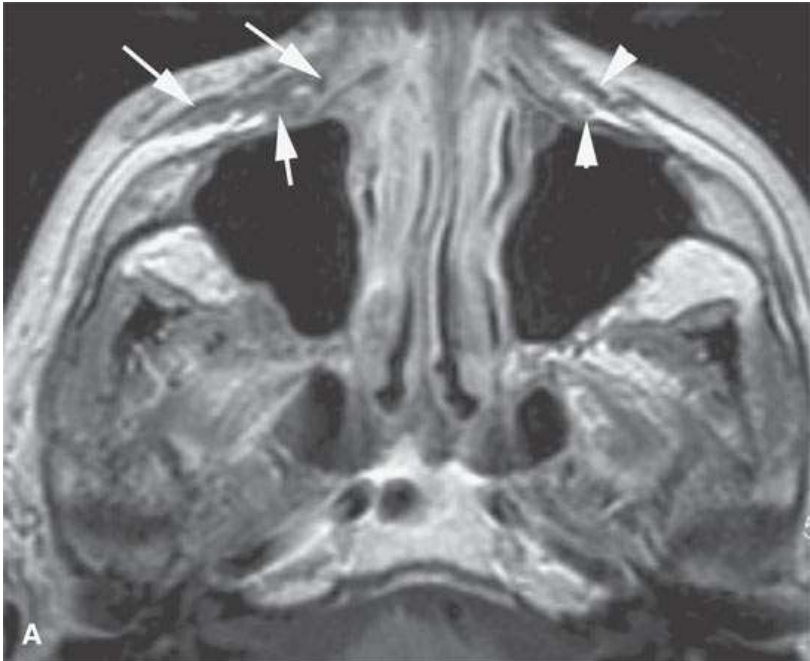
A patient with squamous cell carcinoma of the cheek spread along V2 and limited to the infraorbital canal. The disease was controlled with radiotherapy that spared the eye. A: Computed tomography showing the slightly enlarged bony infraorbital canal (*arrow*) compared to the normal side (*arrowhead*). B: Contrast-enhanced T1-weighted image showing V2 to be enlarged and abnormally enhancing (*arrows*) compared to the normal side (*arrowheads*).
